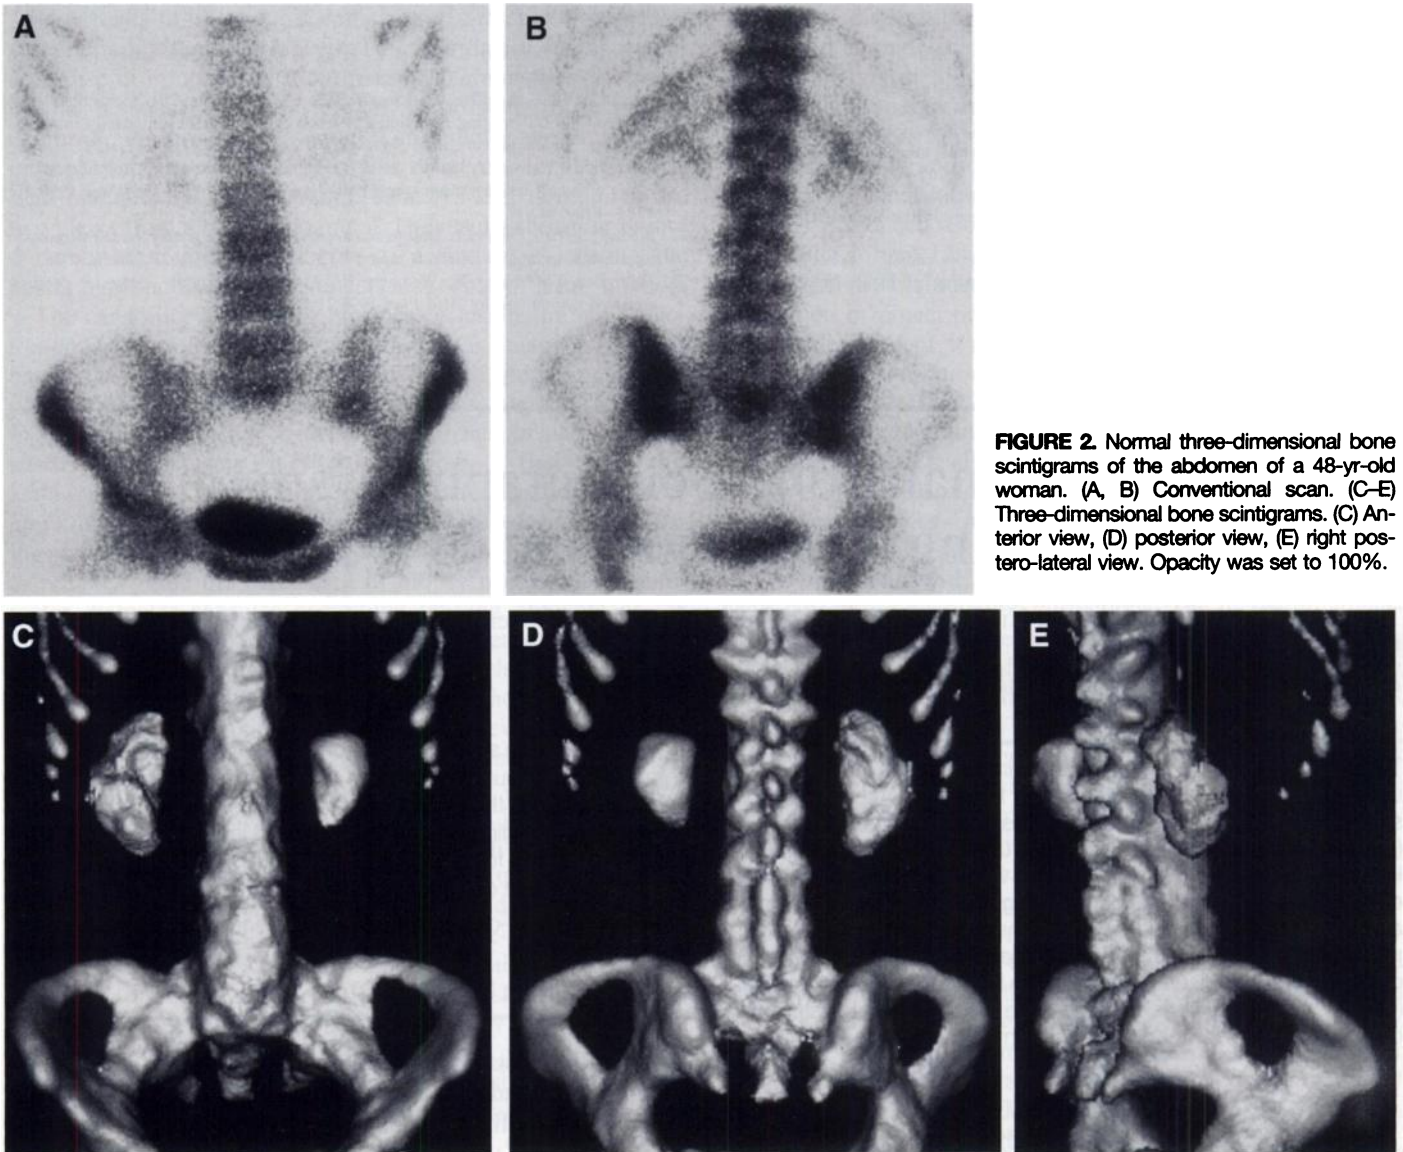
Normal three-dimensional bone scintigrams of the abdomen of a 48-yr-old woman. (A, B) Conventional scan. (C-E) Three-dimensional bone scintigrams. (C) Anterior view, (D) posterior view, (E) right postero-lateral view. Opacity was set to 100%.
